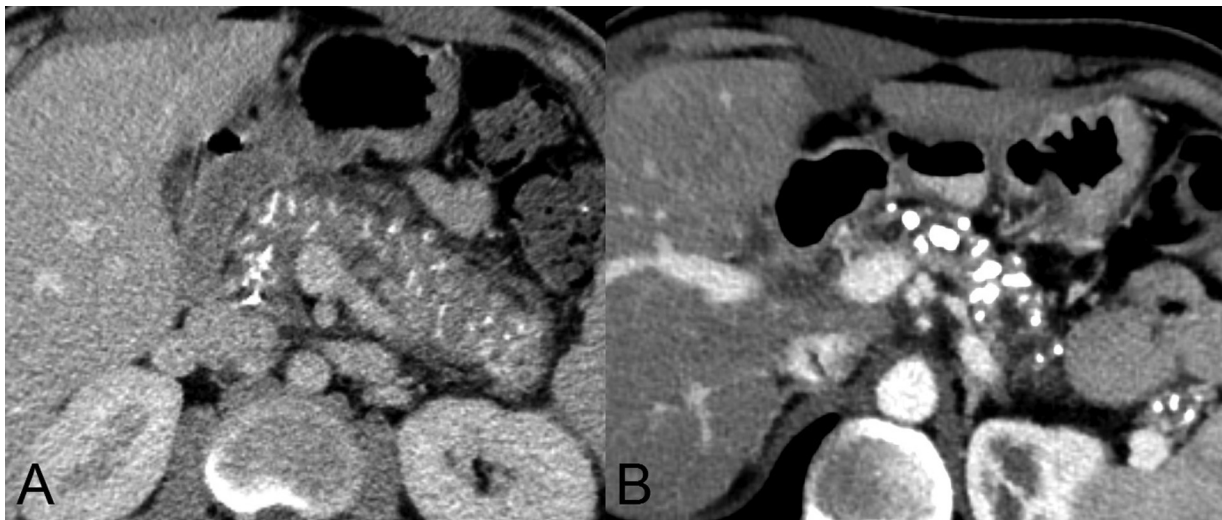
CT images showing examples of types of pancreatic parenchymal calcifications. (A) Diffuse fine punctate calcification. (B) Coarse calcification.
